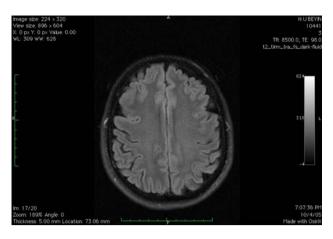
Transverse T2-weighted FLAIR images were obtained to exclude the presence of cranial abnormalities
